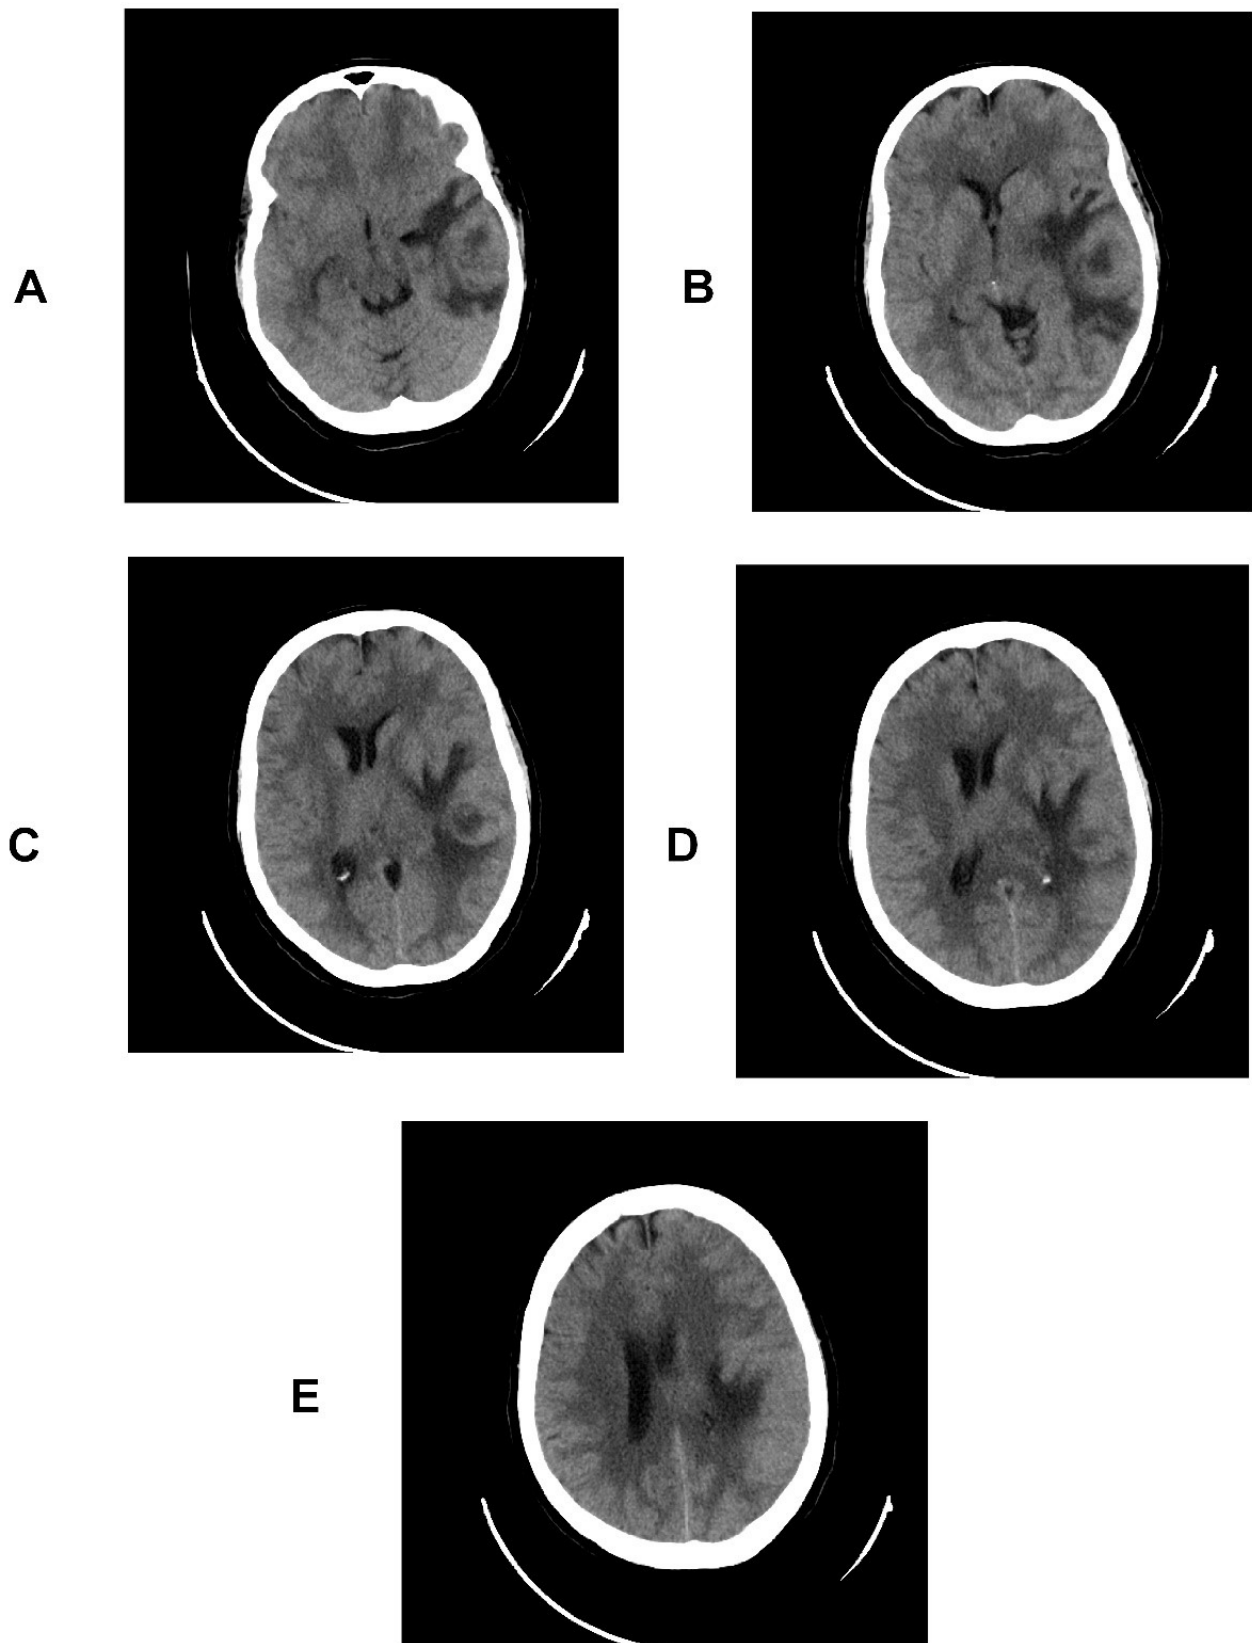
Representative images for the computed tomography (CT) scan. A multi-axial non-contrast CT scan of the brain at the level of the temporal lobe showed a large heterogeneous intra-axial left temporal soft tissue mass (A) with central hypodensity as a cystic component (B,C). It is surrounded by prominent vasogenic edema (hypodense) and a significant mass effect on the surroundings by effacement of the adjacent cortical sulci and obliteration of the atrium and the occipital horn of the left lateral ventricle (A,B,C). Another ill-defined hypodense lesion occupying the left thalamus causes a mass effect represented by a right-sided midline shift (D,E).
